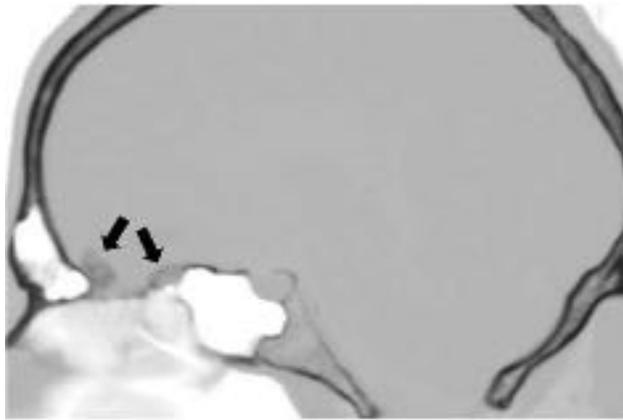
Sagittal CT at bone window settings identifies hyperostosis of the anterior skull base (arrows). Property of the Division of Neurosurgery, University of British Columbia. Used with permission.
